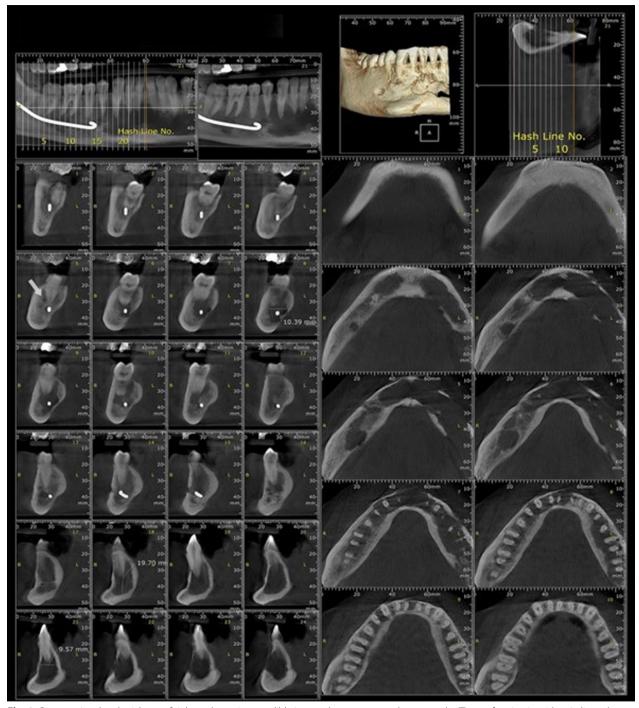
Cross sectional and axial cuts of right and anterior mandible in cone beam computed tomography. The perforation is evident in lingual and buccal cortices
